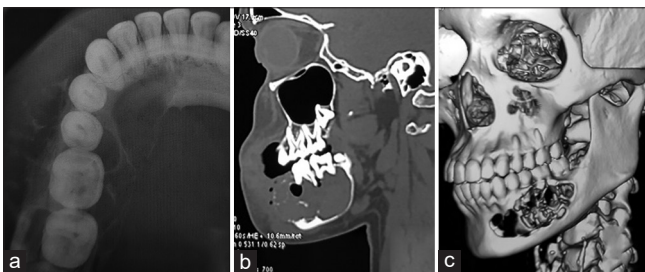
Occlusal radiograph of the left side mandible showing soap bubble appearance (a), and an expansile lytic multicystic lesion of size 5.5 cm × 3.0 cm × 2.7 cm with well-demarcated margin in the body of the left hemimandible on noncontrast computed tomography (b) and three-dimensional computed tomography scan (c) of the face and neck
